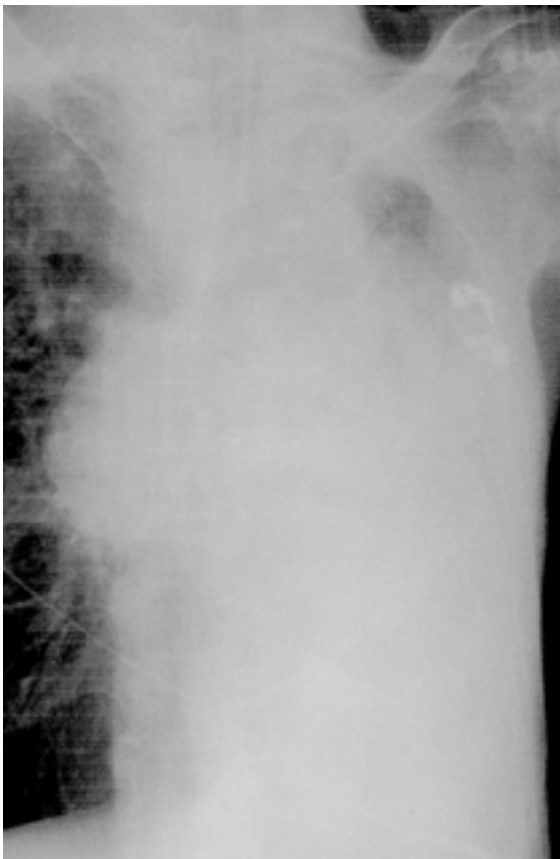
Chest plain film shows near total collapse of the left lung.
